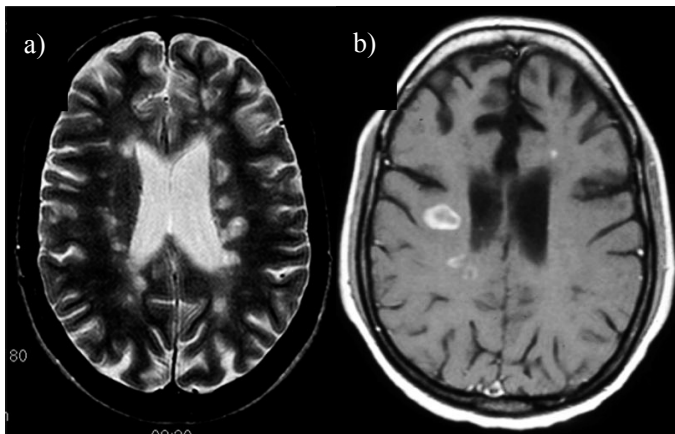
a) T2-weighted magnetic resonance imaging shows white matter lesions. b) T1-weighted contrast enhancing magnetic resonance imaging shows leakage of contrast through a disrupted blood brain barrier in MS.
